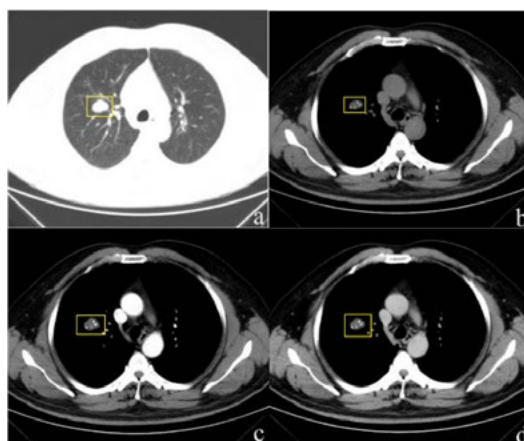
Contrast Enhanced Chest CT
